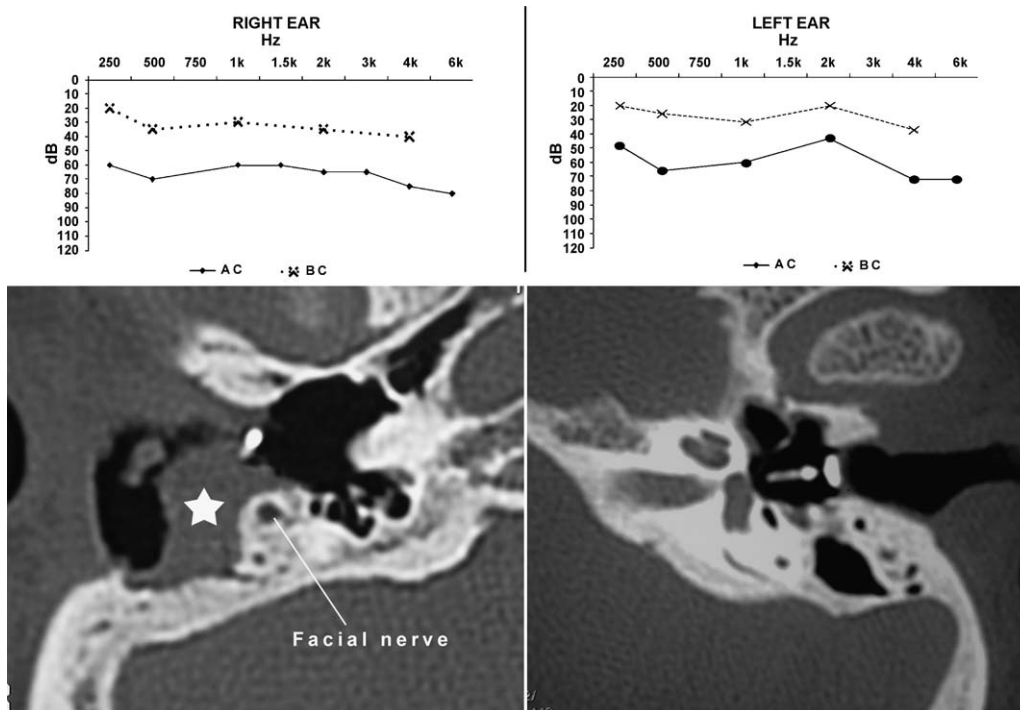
Preoperative auditory and axial CT scan findings of both ears. Both ears present with mixed hearing loss. On the right side, open mastoid cavity with squamous debris (*) and well aerated middle ear space. On the left, lateralization of the tympanic membrane with lateralization of the type III ossicular prosthesis. *AC*: hearing thresholds in air conduction; *BC*: bone conduction thresholds.
